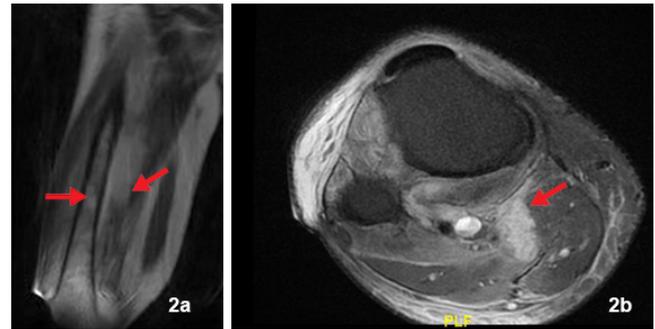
(a) MRI showing osteomyelitic changes in distal femur and thigh abscess (arrows). (b) MRI showing abscess deep to medial head of gastrocnemius (arrow).
